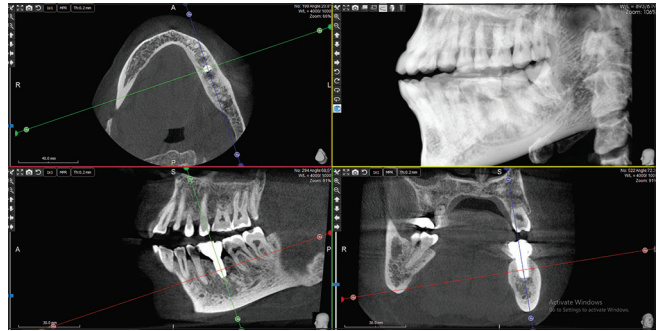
CBCT radiograph obtained 2 years following completion of treatment indicating adequate bone fill and maturation around the implant and distal root surface of tooth #20
